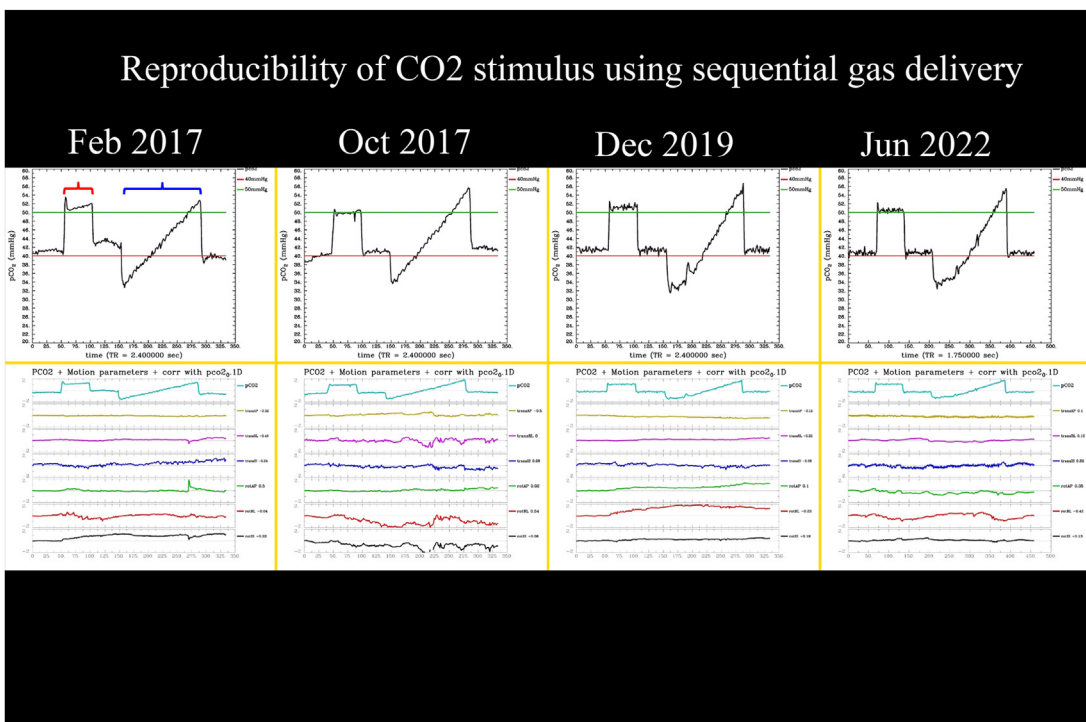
Data in one patient scanned sequentially showing repeatability of the measured end-tidal (exhaled) CO_2 values to the preprogrammed end-tidal CO_2 targets used for each CVR session more than four different CVR sessions. Red bracket is the step stimulus and blue bracket is the ramp stimulus. Bottom graphs indicate head motion in six different axes during MR imaging data acquisition (in millimeters).
